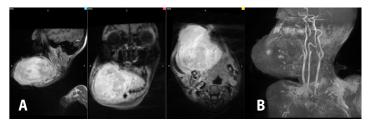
A. MRI, T1 sequence, multiplanar view with gadolinium contrast showing the heterogeneously enhancing mass in the right mandible; B. Time-of-flight window of the patient's MRA showing a branch of the external carotid artery going to the mass from the posterior
